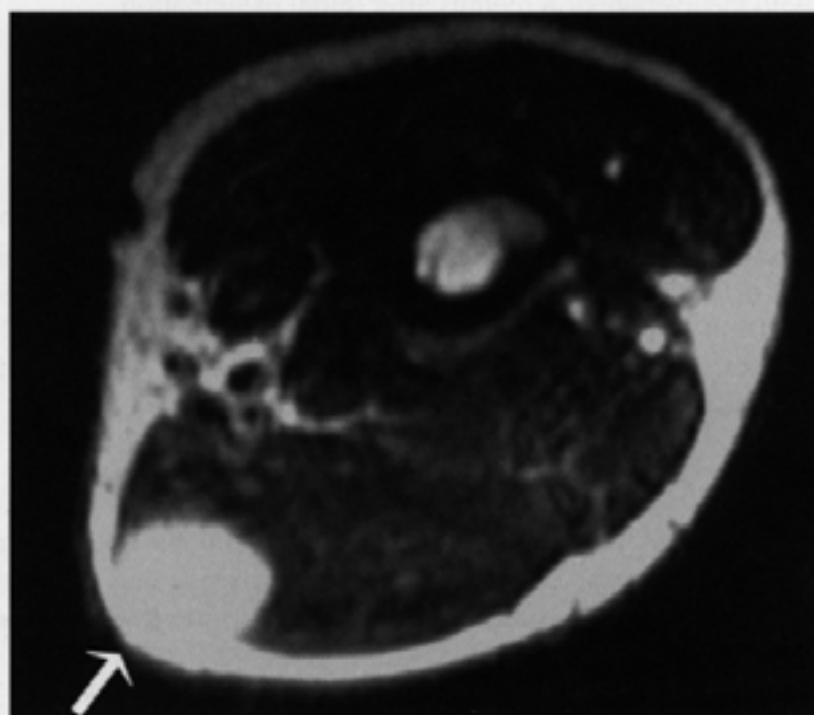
Axial MRIs of 66 year-old male, revealing a tumor (arrow) in the biceps brachii muscle. The mass had a high intensity on a T2-weighted image.
